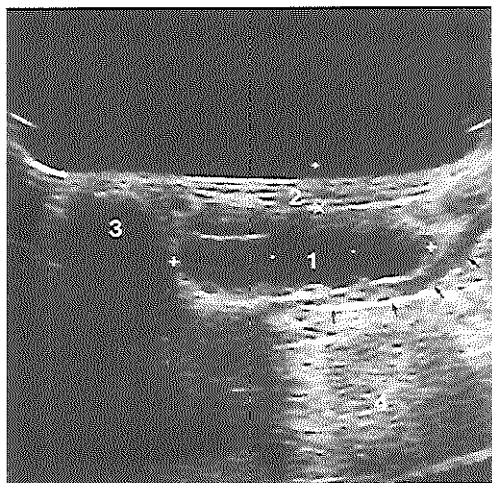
Oblique ultrasound view of the floor of the mouth showing a plunging ranula (1). The plunging ranula is located between the subcutaneous fat (2) and the mylohyoid muscle (arrows). The mandible is characterized by posterior acoustic shadowing (3); The base of the tongue is indicated (4).
